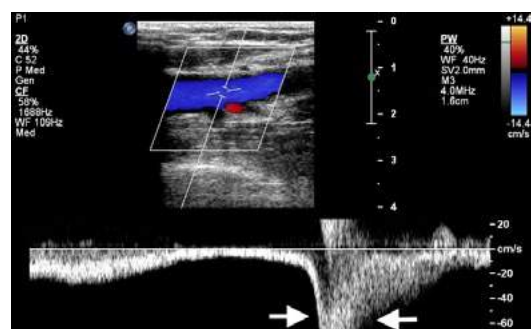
Augmentation of flow through calf compression: spectral doppler image obtained during calf compression (arrows) shows augmentation of flow. This phenomenon helps to exclude thrombosis in deep veins more distal to the examining probe.
